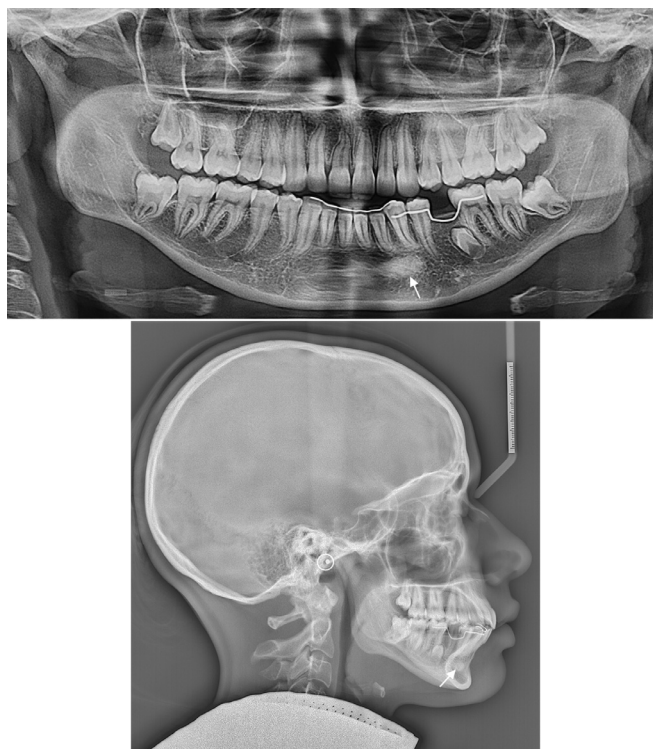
Posttreatment panoramic and lateral cephalometric radiographs after 1-year retention. The arrows indicate the radiopaque bone formation.
